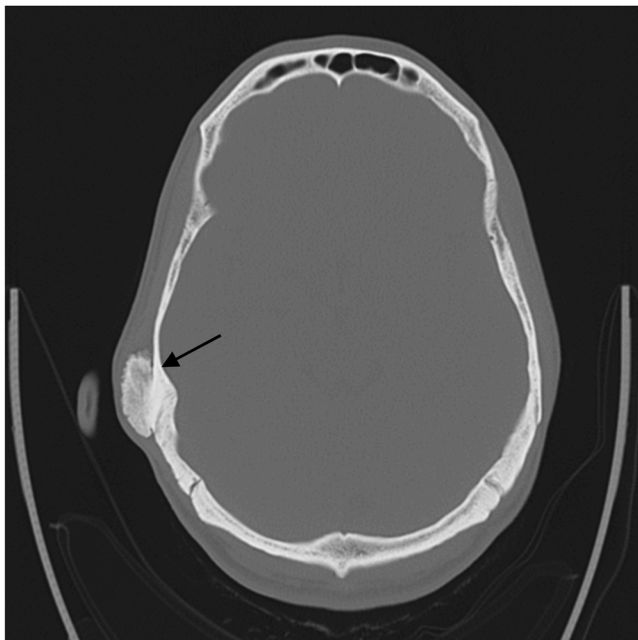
CT scan without contrast: parosteal osteosarcoma of the temporal bone: Solid bony nodule (arrow) measuring 3.1×1.2 cm located on the right temporal bone.
